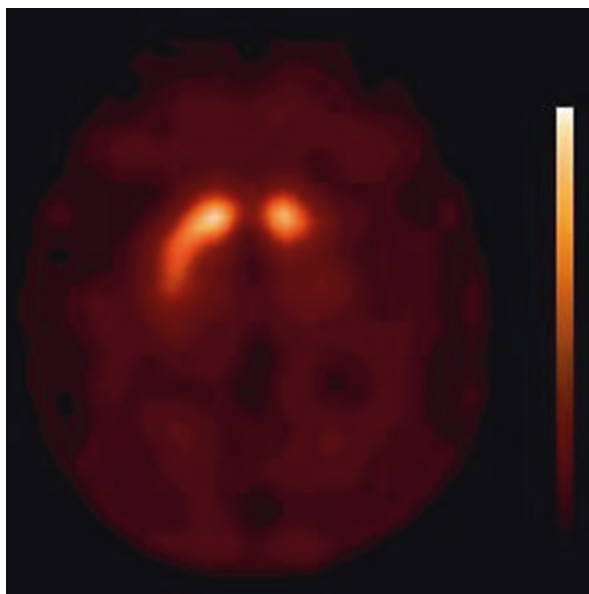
[¹²³I]FP-CIT SPECT scan (3 h after injection) of a hemiparkinsonian patient. Note the asymmetry of binding, as well as the severe loss of binding bilaterally in the putamen
